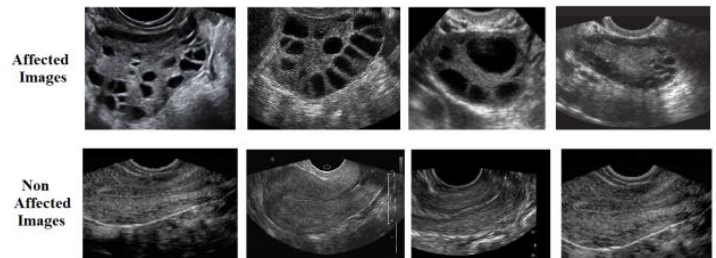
Ultrasound Image Dataset of Endometriosis.
